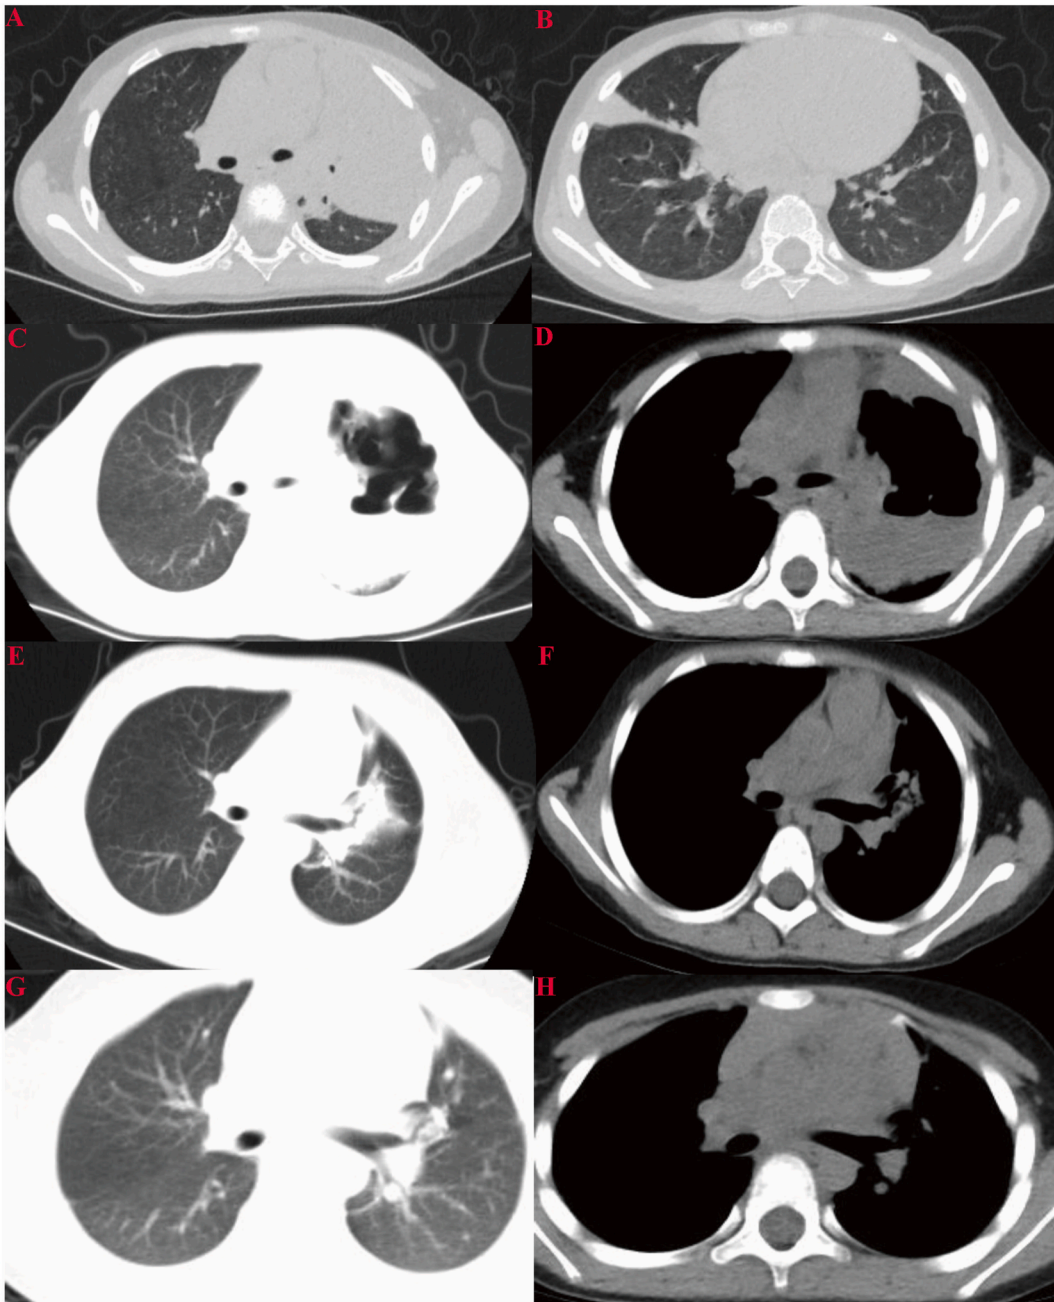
A–B, Chest computed tomography (CT) identified bilateral diffuse parenchymal infiltration, lobar consolidation in the middle and lower lobes of the right lung and the upper lobe of the left lung, and bilateral pleural effusions. C–D, Chest CT was repeated, revealing worsened lung damage. E–F, On the 50th day after admission, chest CT showed lung lesions had partly resolved. G–H, Chest CT lung lesions completely resolved during follow-up.
